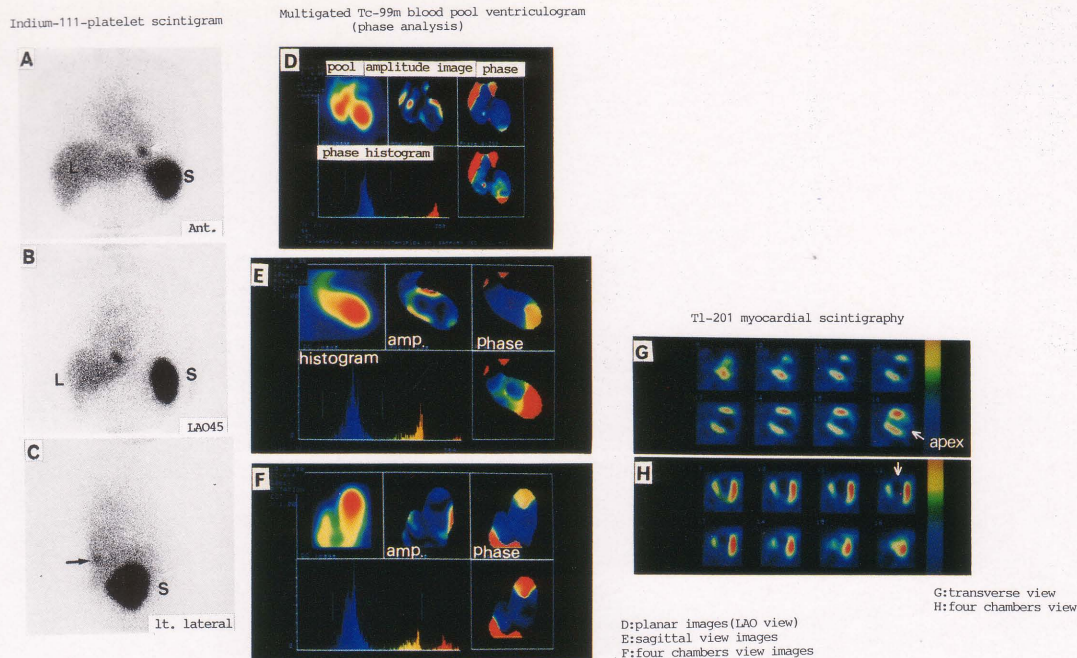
Anteroseptal infarction, apical aneurysm (M.O. 43-years-old male). Indium-111 scintigram (A, B, C) shows active mural thrombus in the apical region of the left ventricle. In this case which had 95% luminal diameter stenosis of the left descending artery and 75% luminal diameter narrowing of the right coronary artery on arteriography, Tl-201 myocardial SPECT scans (G, H) show perfusion defect of apical wall and divergence of the LV walls. The amplitude image and phase image of the first Fourier coefficient calculated from the Tc-99m blood pool image data show marked LV enlargement and dyskinesia in the infarct apical wall (D, E, F).
